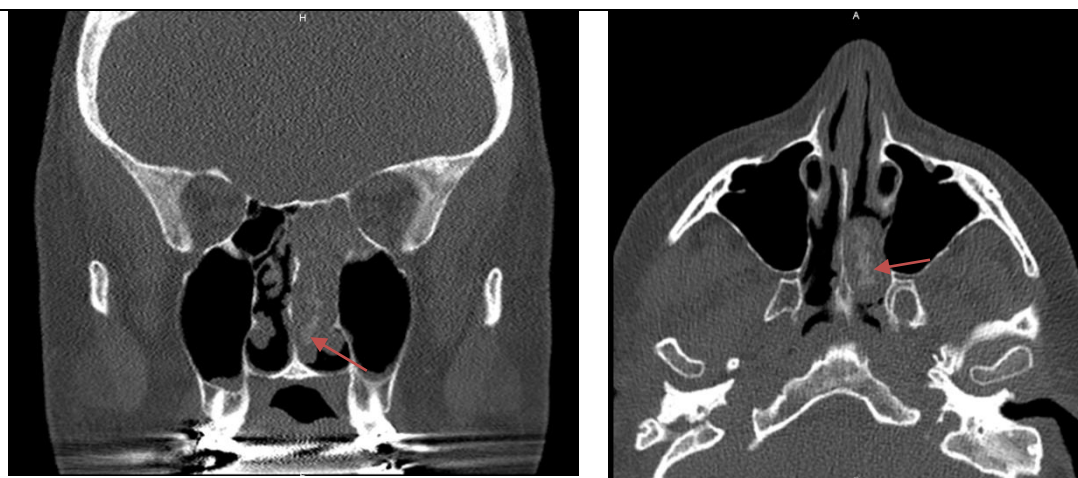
8 years later coronal and axial CT (bone window) showing the progression of the mass reaching below the lower edge of the inferior turbinate. Note the presence of a calcified core in the mass (arrow).
